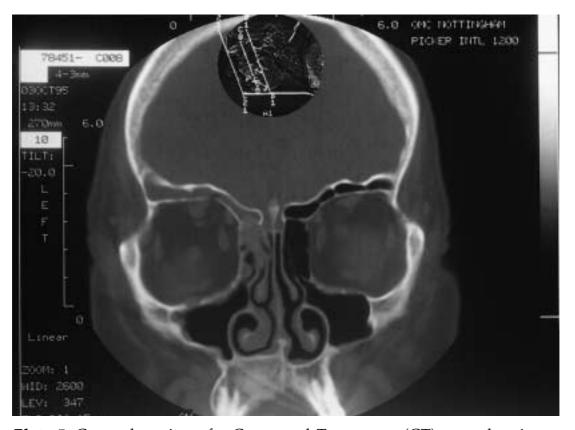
Coronal section of a Computed Tomogram (CT) scan showing a section through the eye sockets, nose and sinuses.
